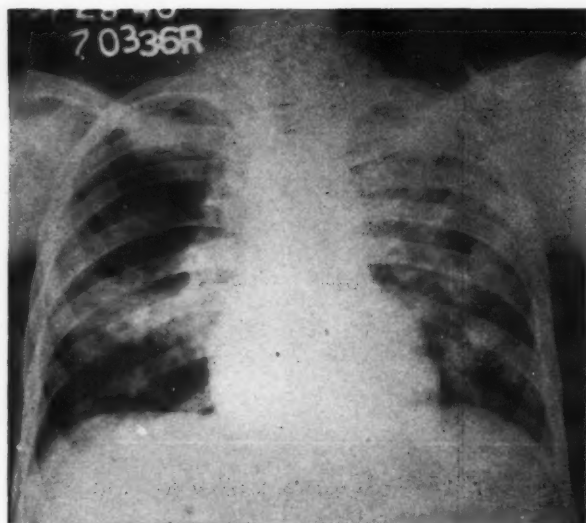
Case II. Letterer-Siwe's disease. X-ray of chest showing mottled infiltration and honeycombing.
